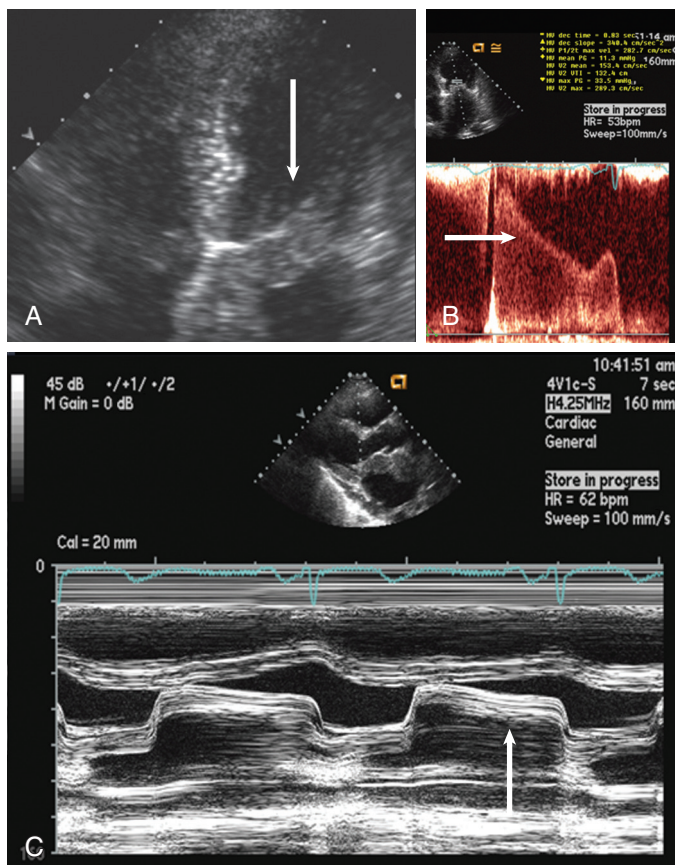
Echocardiographic Doppler images from a patient with sarcoma evaluated because of heart failure and mitral stenosis. A, Four-chamber image with mitral valve thickening (arrow). B, Increased velocity across the mitral valve showing stenosis (arrow). C, M-mode showing a classic mitral stenosis pattern (arrow).
